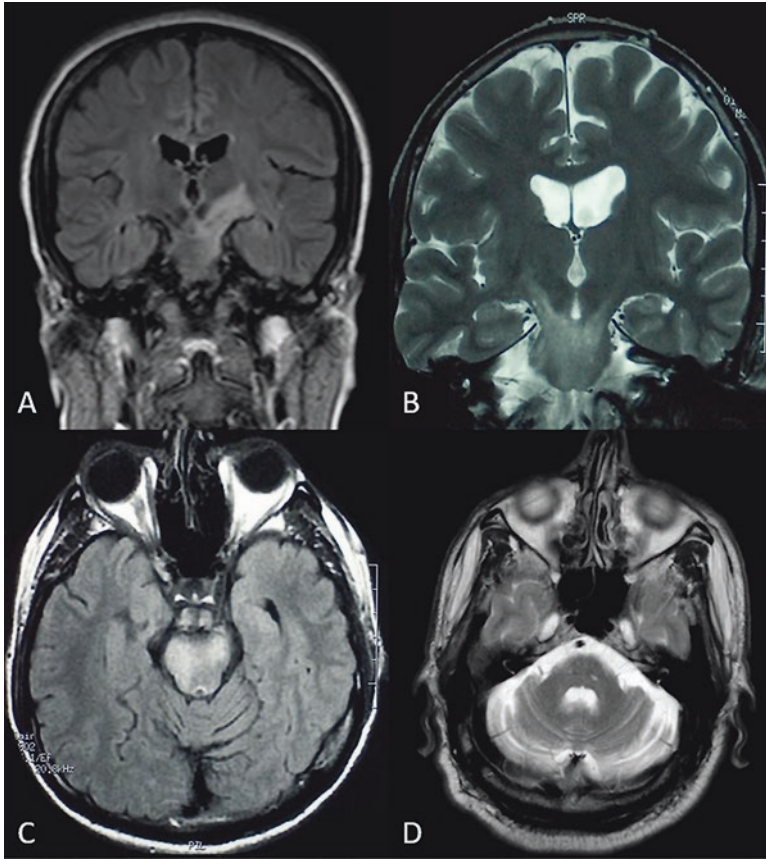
MRI samples of NBD patients. (a, b, c) Acute brainstem lesions with a characteristic appearance. (d) In chronic term, prominent atrophy in the brainstem and cerebellum is evident
